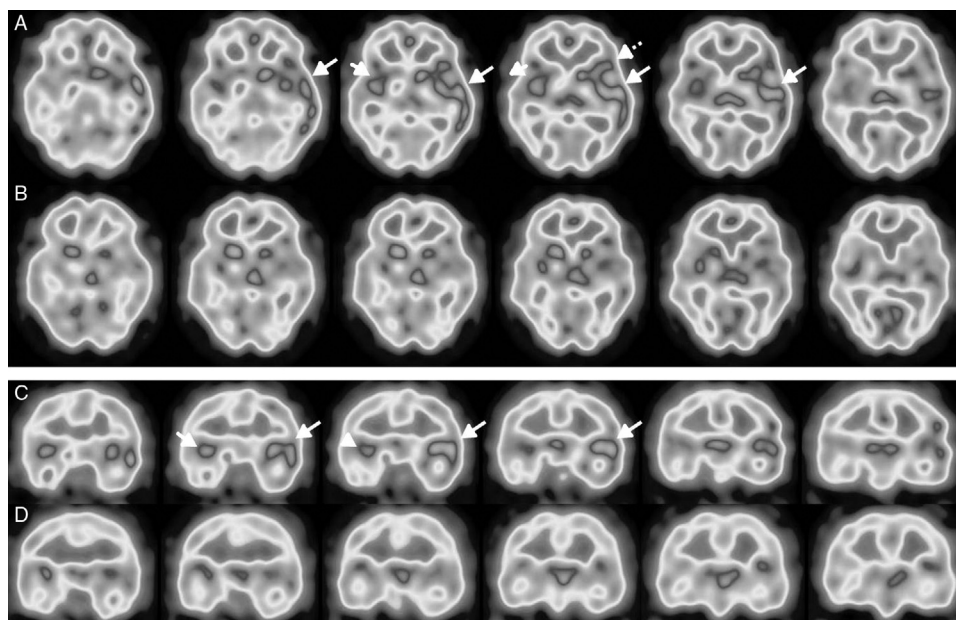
Brain perfusion SPECT scan with ^{99m}Tc -HMPAO, performed at diagnosis. Axial (A) and coronal (C) sequences showing hyperperfusion in the left temporal cortex (long arrows), predominantly in the superior lateral area and the insula, and extending to the adjacent frontotemporal area (Broca area) (dotted arrow). Hyperperfusion was less marked and less extensive in the right temporal cortex (short arrows). A follow-up study conducted after 5 months (B and D) revealed nearly complete resolution of abnormal brain perfusion.
